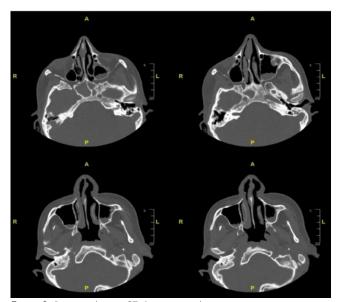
Paranasal sinus CT-demonstrated sinusitis
